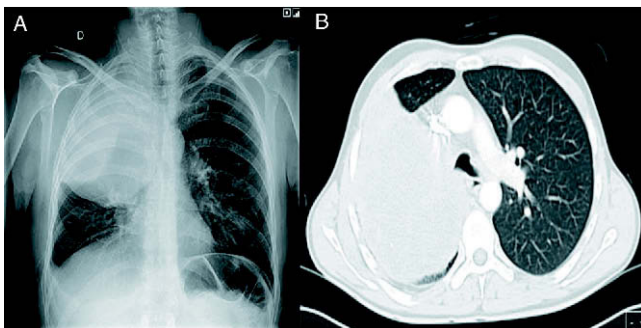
A) Posteroanterior chest radiography showing a large mass in the right upper lobe. B) Thoracic computed tomography of the patient.
